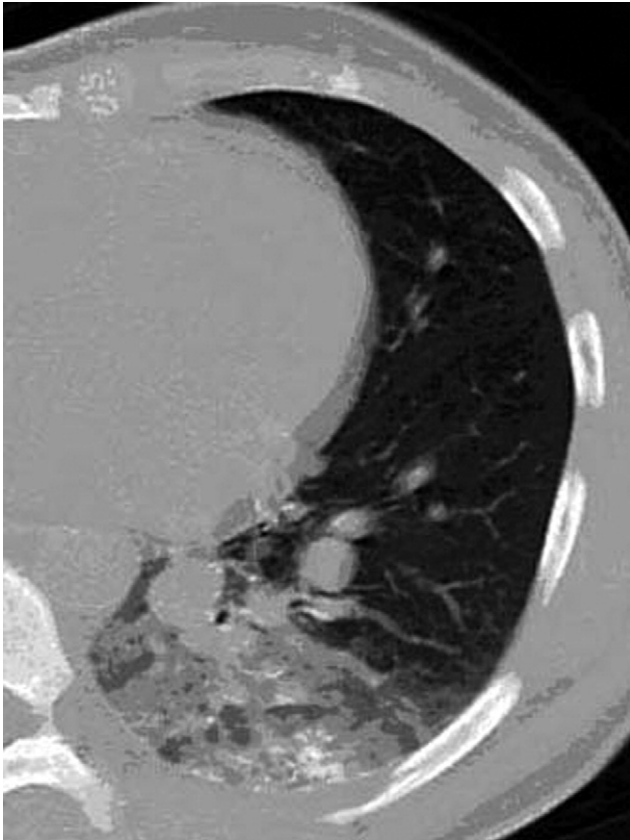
Noncontrast chest CT scan after first treatment shows uptake of ethiodized oil within left lower lobe nodule.
